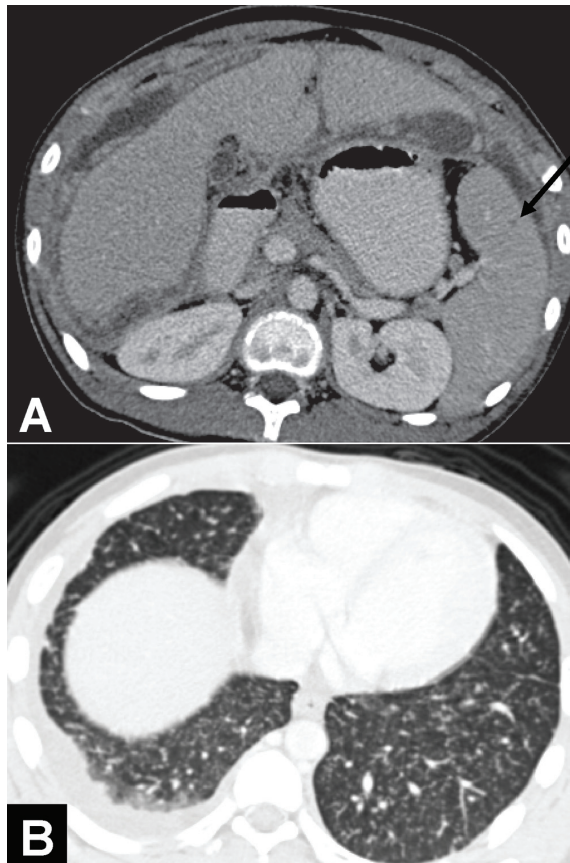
Tuberculous peritonitis A) Axial image of contrast enhanced CT abdomen showed splenomegaly with miliary nodule (arrow) B) Lung window revealed multiple miliary nodules in both lung bases
